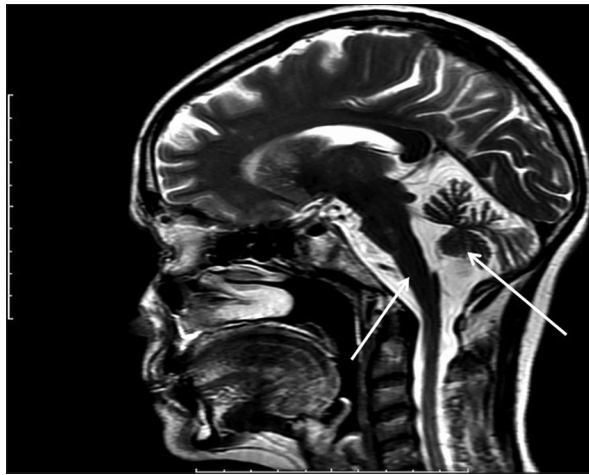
Sagittal T2-weighted magnetic resonance imaging (MRI) showing gross atrophy of brainstem and cerebellum with widening of extra-axial cerebrospinal fluid (CSF) space (white arrows)
